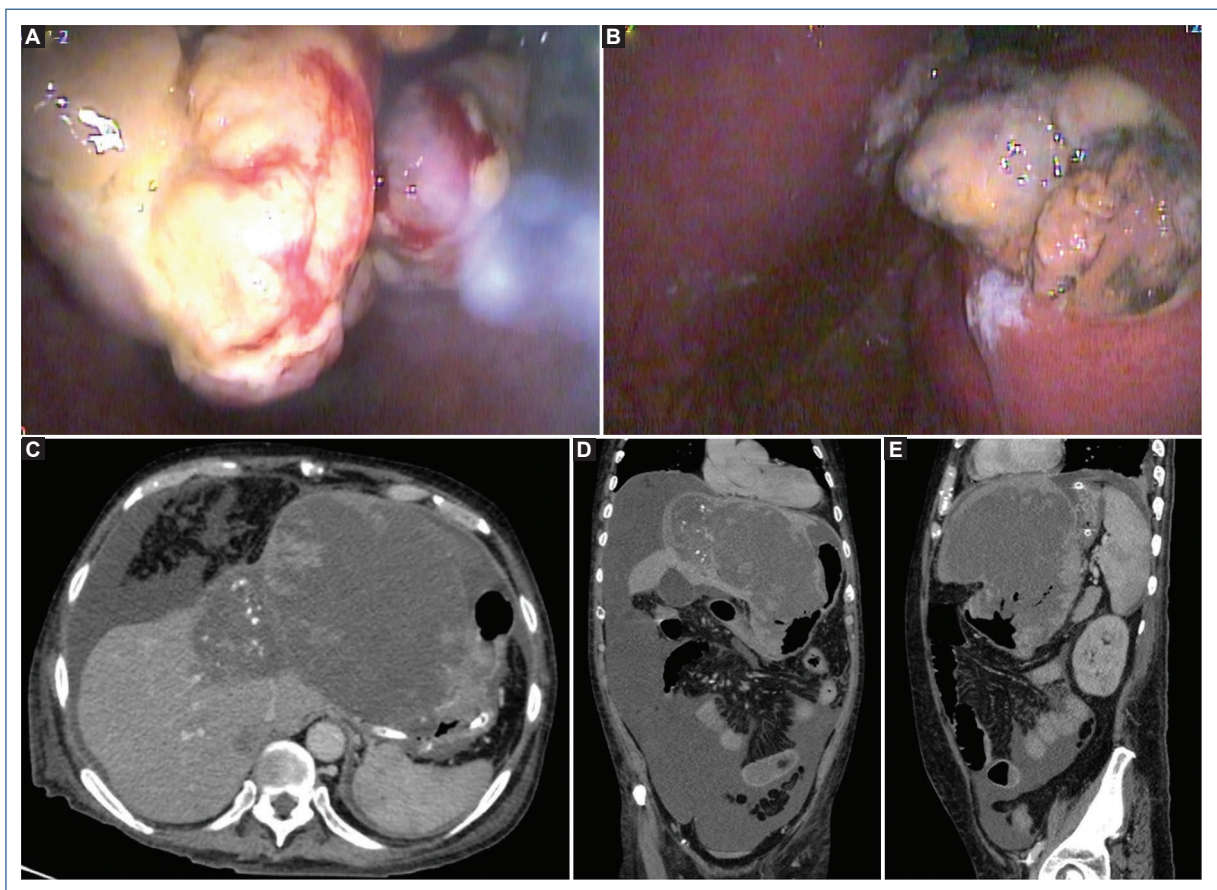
A: upper endoscopy. Indurated extraintestinal mass invading the lesser curvature of the stomach extending through the infiltrating site up to the antrum. B: endoscopic view in retroflexion. C: CT scan axial view revealed a multinodular lesion in the hepatic segments II, III, and IV with measurements of 17 x 16 x 14.5 cm and a volume of 2050 mL. D: coronal section showing tumor invading the stomach. E: sagittal section with displacement of intestinal structures.
